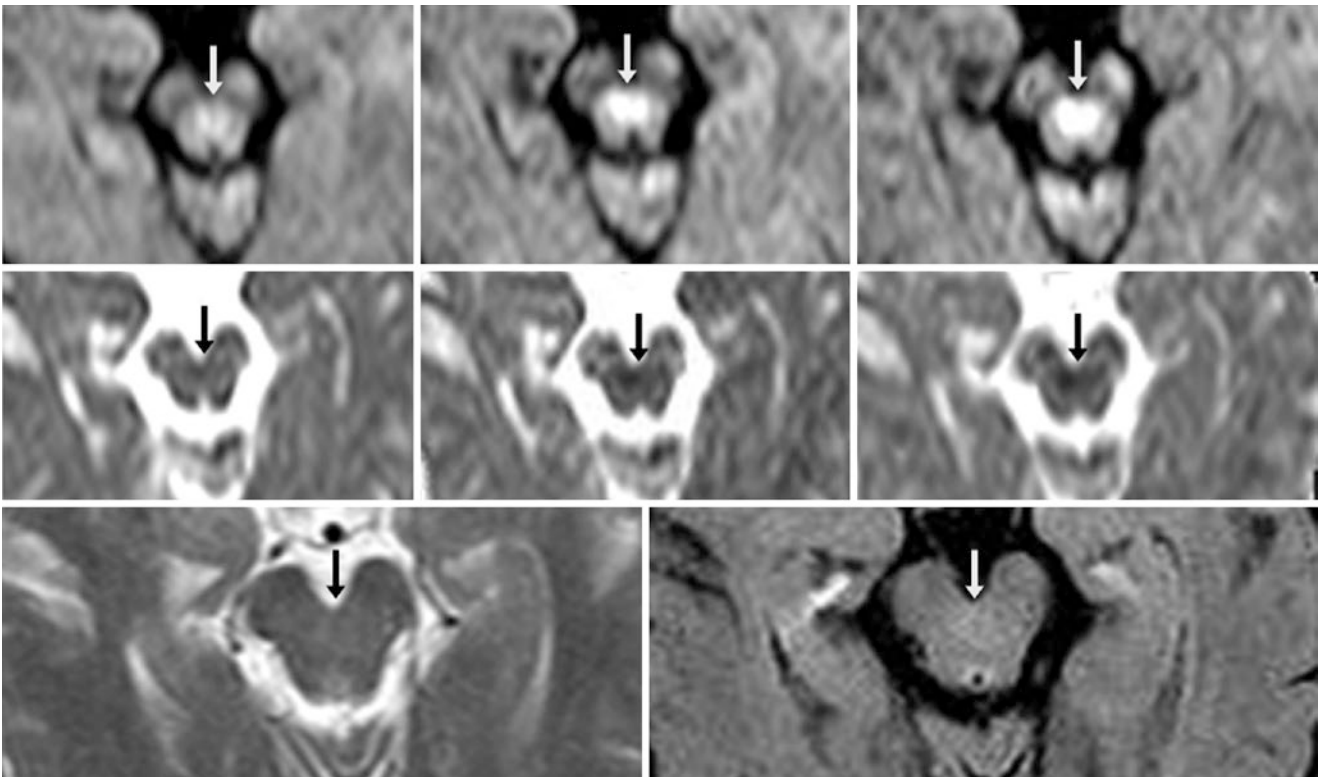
An 81-year-old with a 1.5 T MRI. *Top row:* A $b=1000$ DWI (*left*) shows normal mild hyperintensity of the DSCP (*arrows*), which is increasingly visible at b values of 1500 (*middle*), and 2000 (*right*) s/mm^2 . The brightness is due to intense white matter anisotropy
